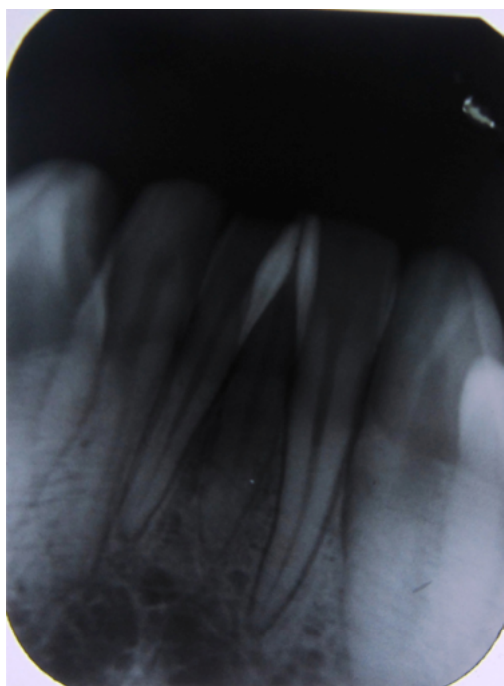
Intraoral radiograph of mandibular anterior segment (Case 2)
